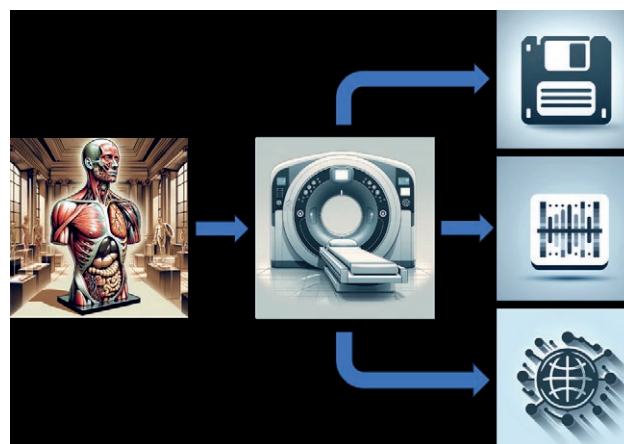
Use of Computed Tomography (CT) tool. Reconstructing anatomical models through CT scans results in a virtual representation, providing insights into the various techniques used and contributing to the development of a multi-level accessible virtual museum project.
